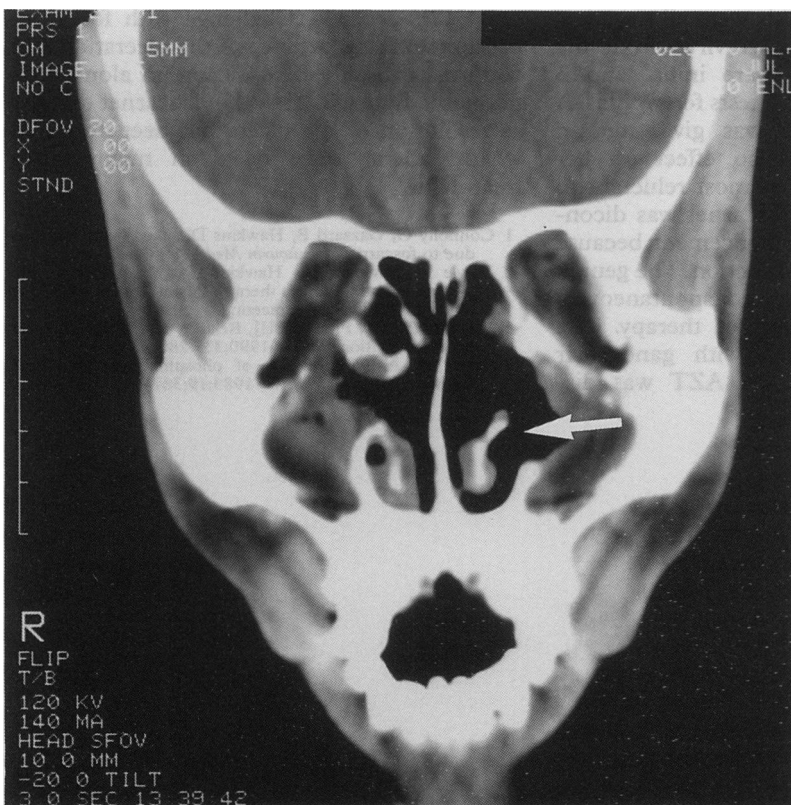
Oblique coronal CT post albendazole showing regression of opacification and deficiency of the medial wall of the left maxillary antrum (arrowed).
